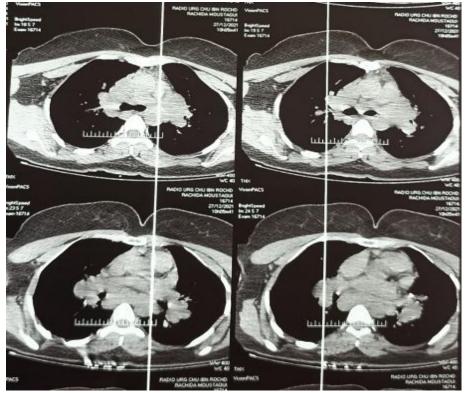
Chest CT scan on the mediastinal windows show multiple centimetric lymphadenopathies involving all the mediastinal territories, bilateral, symmetrical, non-compressive, without necrosis, without pleuropericardial effusion.
